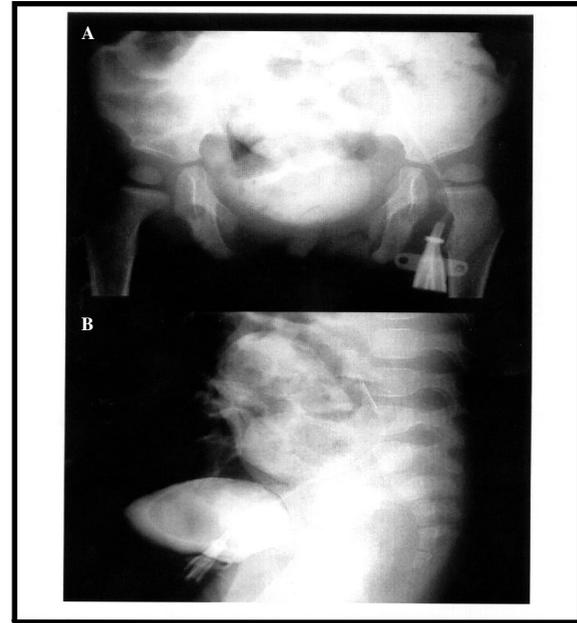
Radiological photograph showing: (a) Plain x-ray showing wide separation of pubic bones; (b) Cystogram showing urinary bladder herniating through the lower abdominal wall defect.
